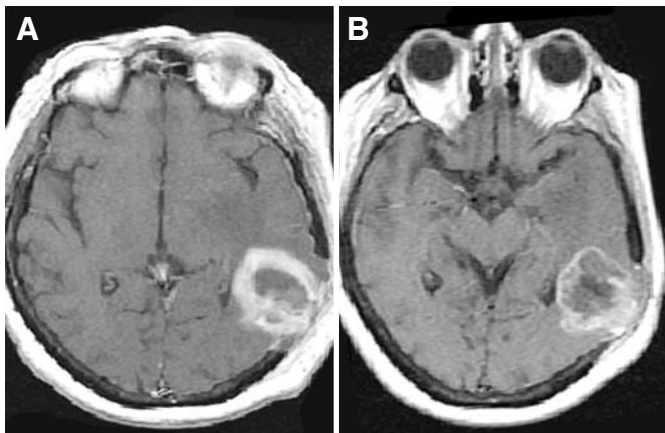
Enhanced T1-weighted MRI scans obtained from Patient 2 before (A) and after (B) MRIgFUS treatment. Note the loss of enhancement at the treated site.
